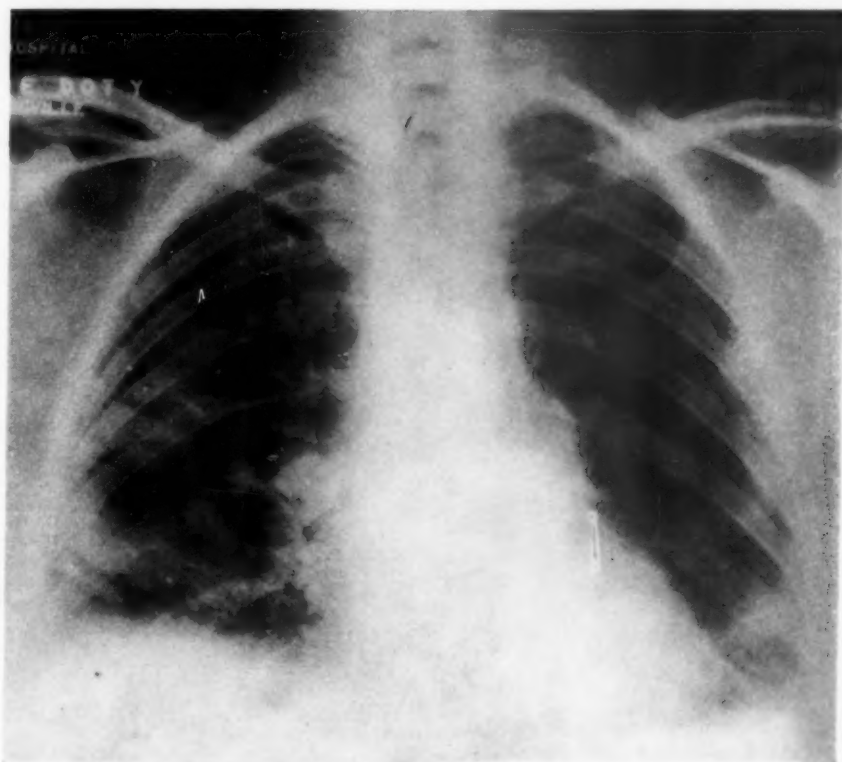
Roentgenogram of chest taken on admission, July 13, 1940.
